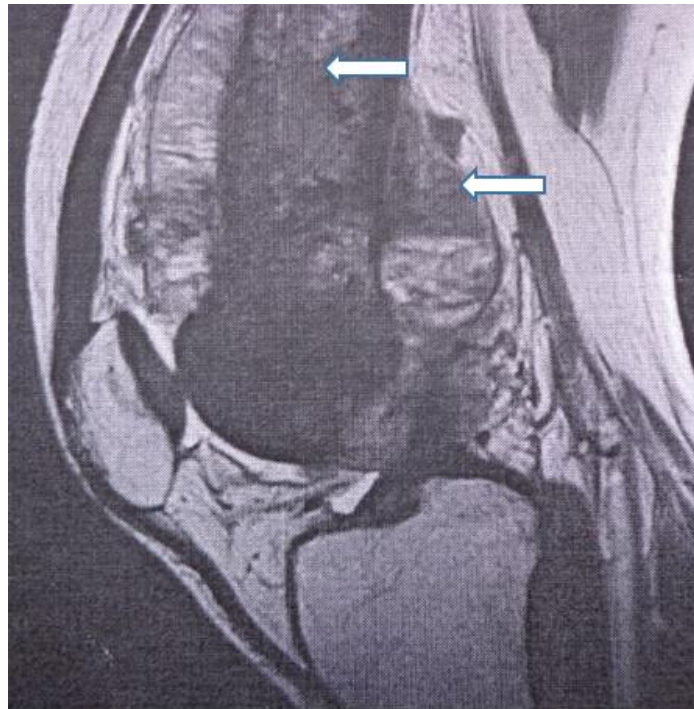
MRI of the knee joint in a 17-year-old girl. Osteogenic sarcoma of the distal femoral end. Metaphysis and epiphysis are almost destroyed. Cancer-associated periostitis. Spicules that grow into the surrounding tissue
